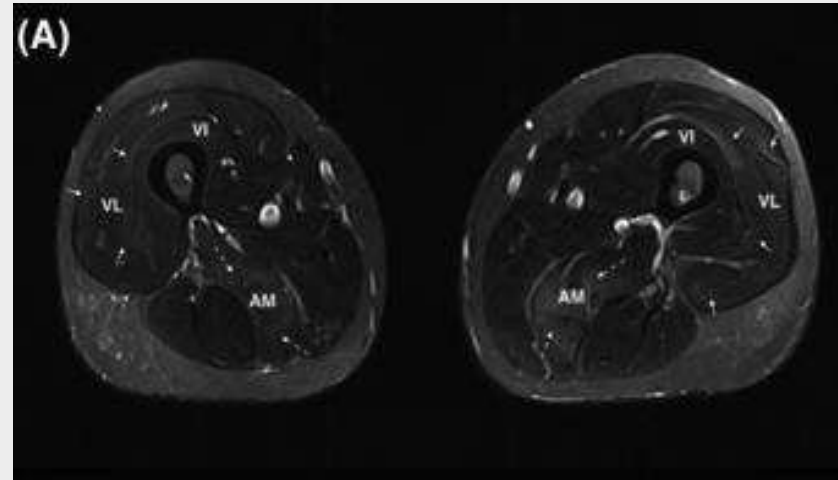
High muscle T2 signals in myositis: (A) Thigh muscle MRI in Scleroderma/myositis overlap showing mild muscular inflammation. Normal muscles appear with a very low signal (close to the subcutaneous tissue after fat signal suppression).
